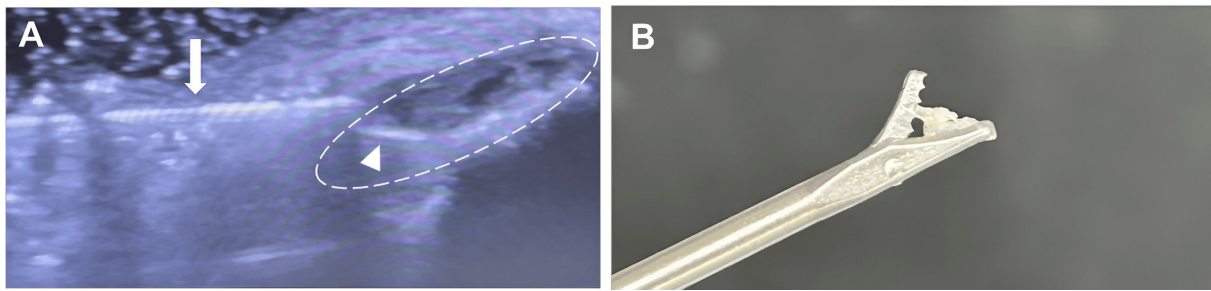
Minimally invasive US-guided biopsy technique of the CET enthesis. (A) US-guided biopsy technique, the guide needle (arrow) is inserted up to the target area of the CET enthesis (dashed line) where the tip of the nano-forceps is opened to collect tissue (arrowhead). (B) Nano-forceps tips with the enthesial sample collected. CET, common extensor tendon; US, ultrasound.
